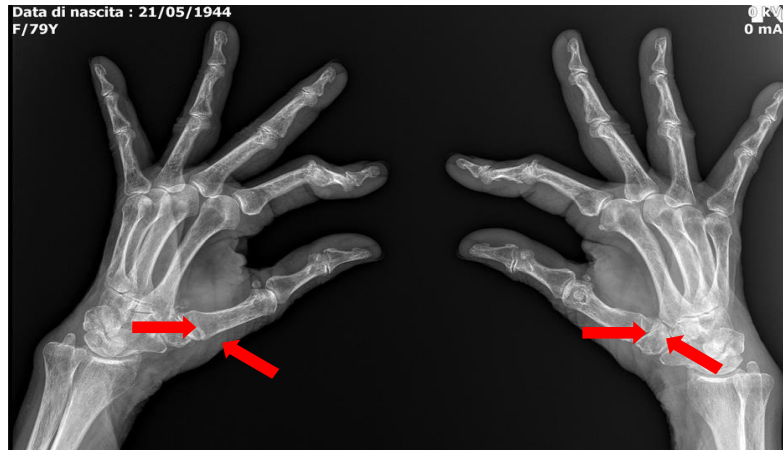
Latero-lateral radiographic projection of both hands documenting grade 2 bilateral rhizarthrosis with slight joint space reduction.
